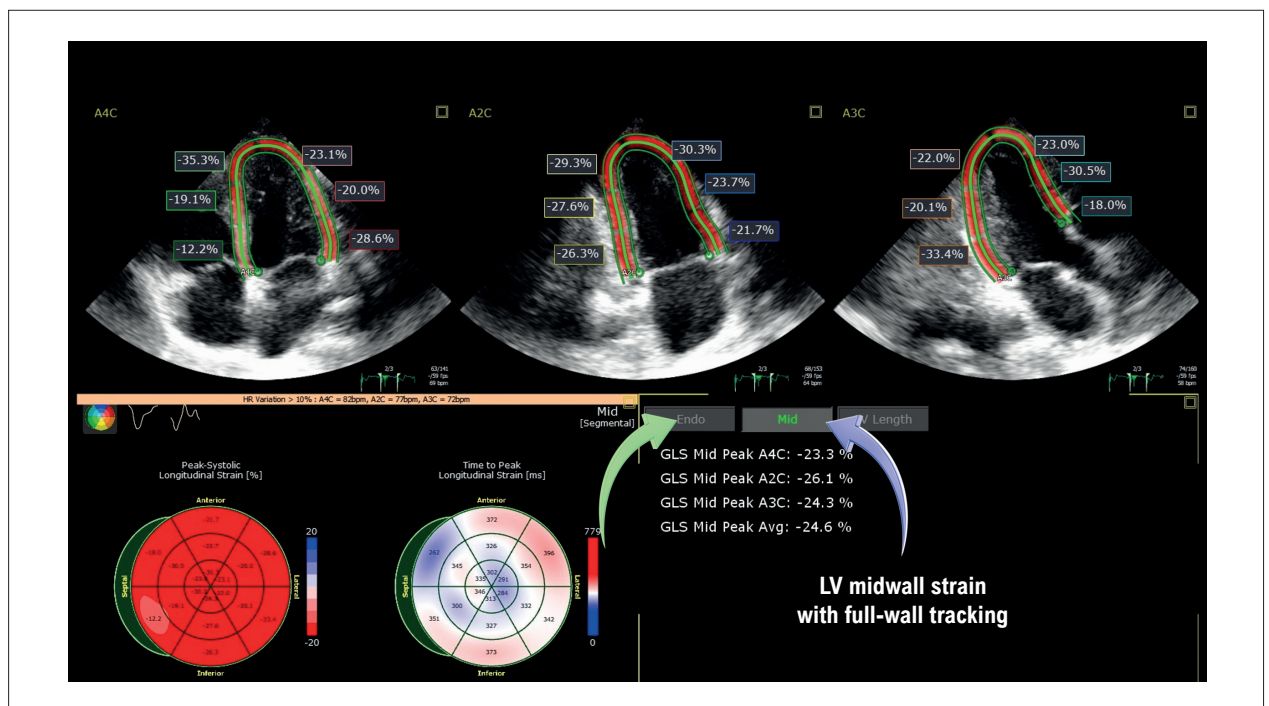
Assessment recommended by the ASE and the EACVI¹ regarding the myocardial segment tracked for the analysis of LV GLS, as well as the description of the final value (blue arrow). Despite the recommendation to use the midwall segment of the left ventricle, echocardiography software still allows assessment of other segments, such as, in this case, the endocardial segment (green arrow). LV: left ventricular.
